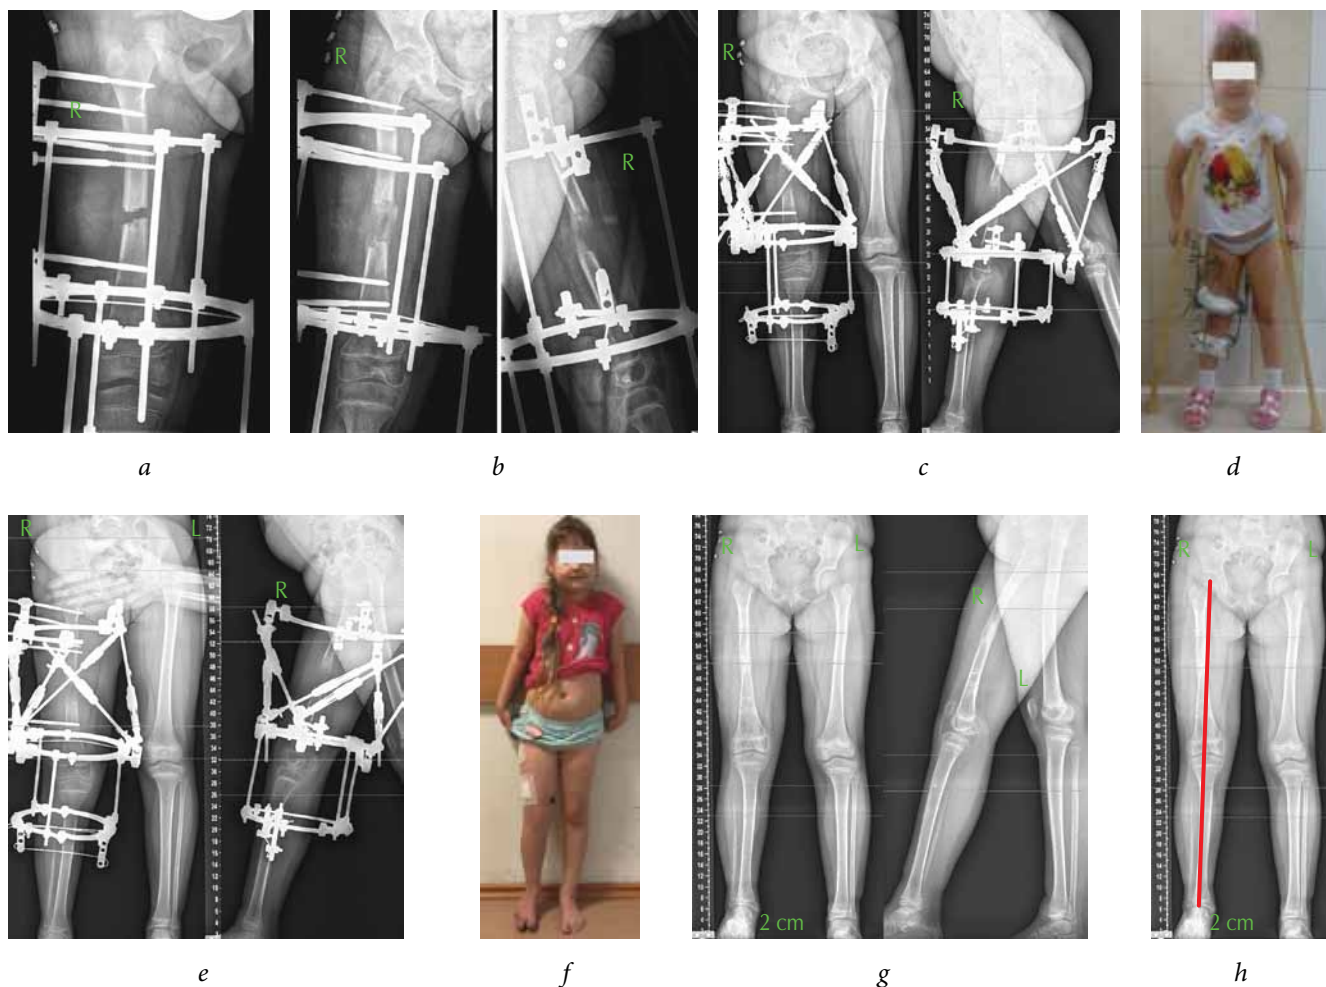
Patient P. at the second stage of treatment: *a, b* — radiographs at the stages of elongation; *c* — panoramic radiographs of the lower extremities after the unit Orto-SUV installation; *d* — photo of the patient with the apparatus; *e* — panoramic radiographs of the lower extremities after the deformity correction; *f* — photo of the patient after CDA dismantling; *g, h* — panoramic radiograph after CDA dismantling
